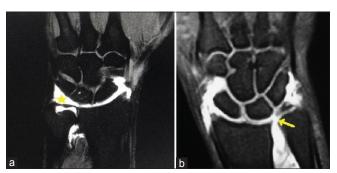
Triangular fibrocartilage complex tears on magnetic resonance arthrography, (a) triangular fibrocartilage complex central perforation (yellow star) – leak of contrast from radiocarpal joint to distal radioulnar joint is seen on a coronal T1-weighted fat saturation magnetic resonance arthrography image, (b) tear of the radial attachment of triangular fibrocartilage complex (yellow arrow) – as seen on coronal T1-weighted fat saturation magnetic resonance arthrography image
